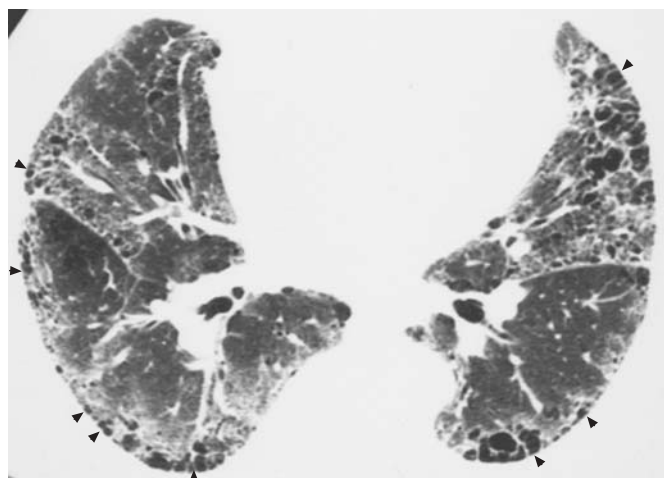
A computed tomography image through the lower lungs in a patient with idiopathic pulmonary fibrosis showing predominantly subpleural honeycombing (arrowheads).
